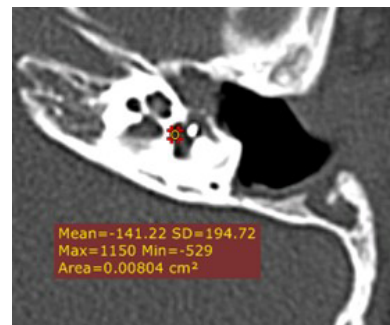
Computed tomograms of the temporal bones, axial view. Condition after stapedectomy and stapedoplasty. Cholesteatoma masses of the tympanic cavity
